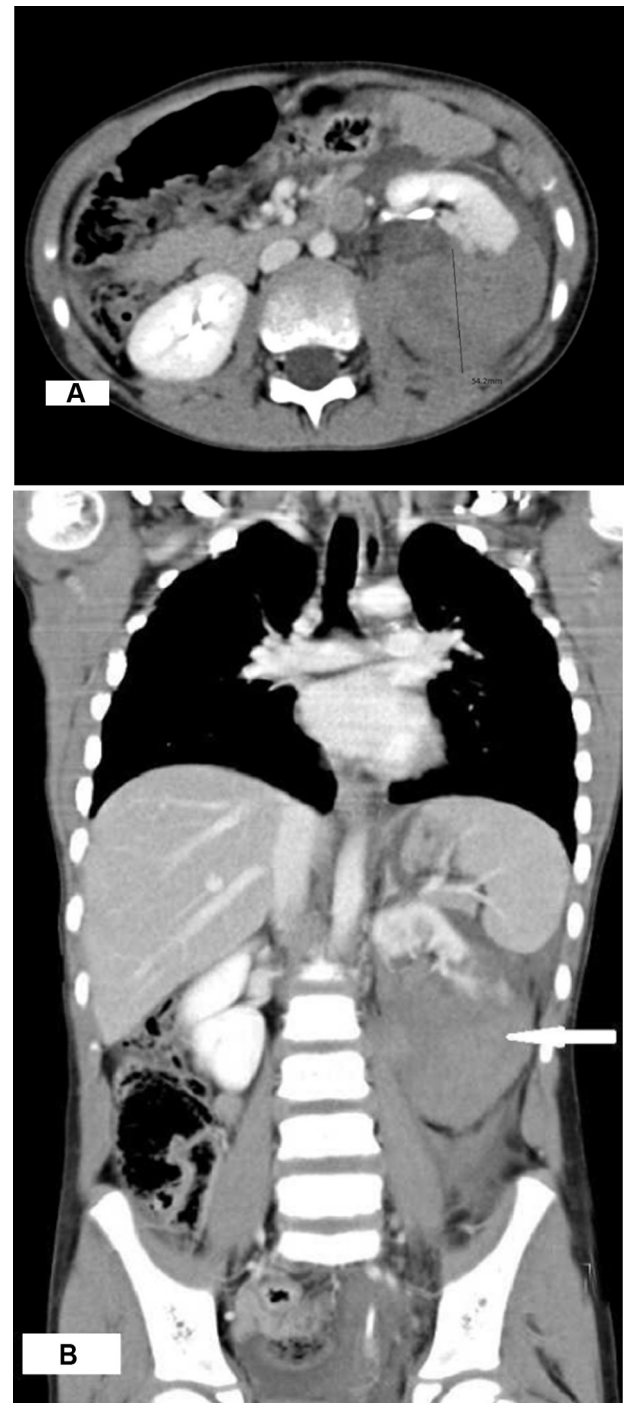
Contrast enhanced CT scan for a patient with blunt renal trauma during the portal venous phase, (A) axial and (B) coronal MPR reformatted image reveals left renal injury with large tissue-attenuation perirenal hematoma posterior to the kidney measuring 54.2 mm.
